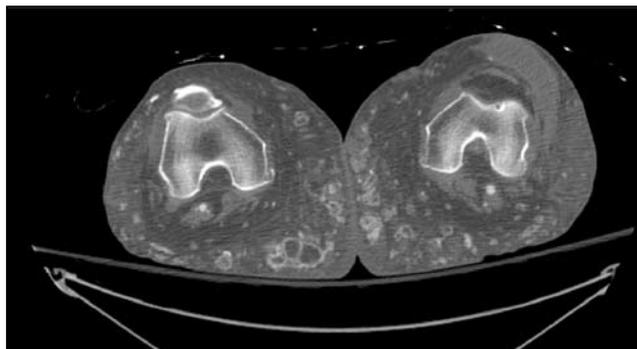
(above and left) Axial and coronal images from a CTA of the lower extremities, bone windows.
